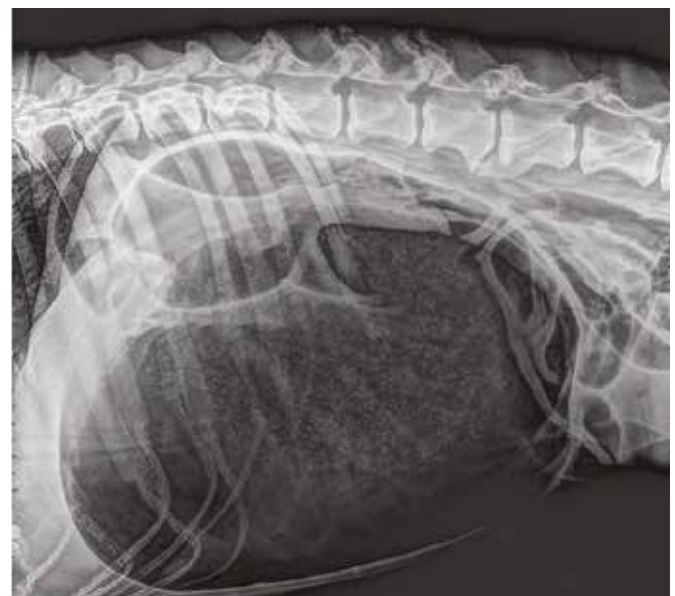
Right lateral abdominal radiograph showing gastric dilatation–volvulus. Note the characteristic double bubble or reverse C appearance caused by dorsal displacement of the pylorus.
